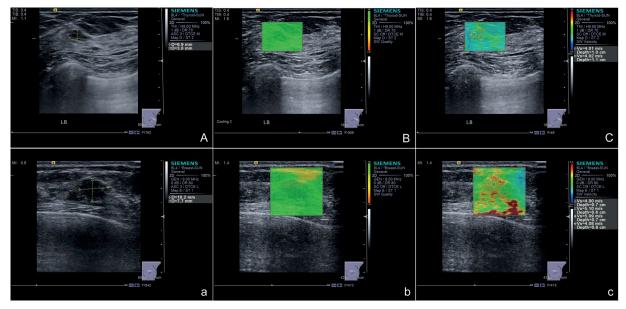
Multimode ultrasound examination for DCIS of the breast with (a, b, c) or without invasive components (A, B, C). (A and a) for B-mode ultrasound, (B and b) for shear wave quality of VTIQ, and (C and c) for SWV assessment in VTIQ. DCIS: ductal carcinoma *in situ*, VTIQ: virtual touch tissue quantification, SWV: shear wave velocity.
